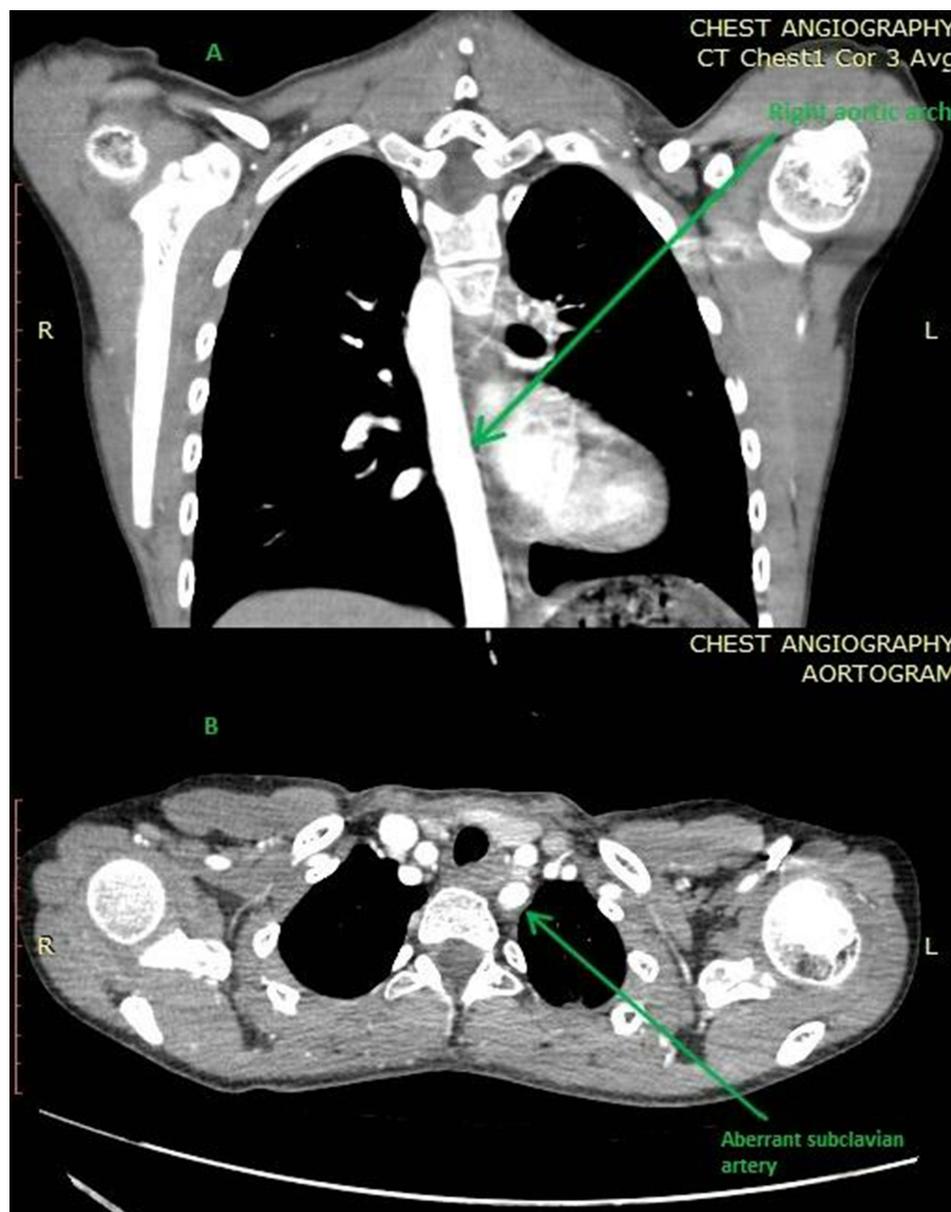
Chest CT showing right aortic arch (A) and aberrant origin left subclavian artery (B).
